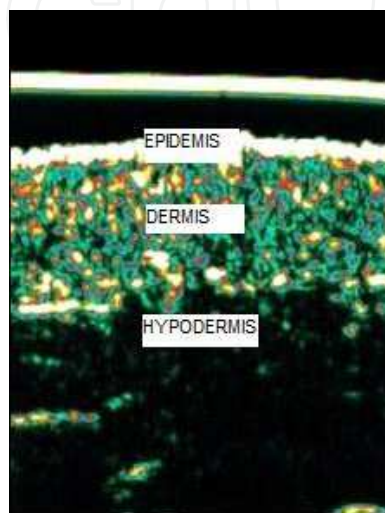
Ultrasound image of the skin: epidermis, dermis, hypodermis
